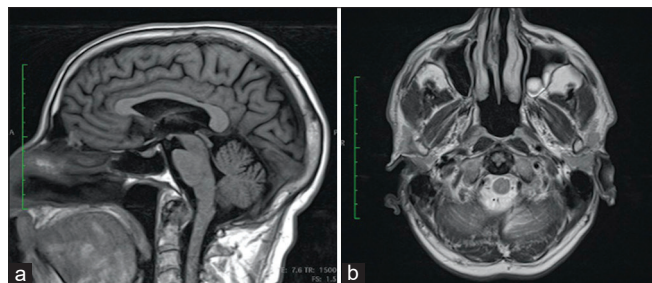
Sagittal (a) and axial (b) sections of magnetic resonance images of the craniocervical junction, presenting an expansive lesion in the posterior aspect of the odontoid process, with low signal at both T1 (a) and T2 (b). There is no evidence of spinal cord compression.
